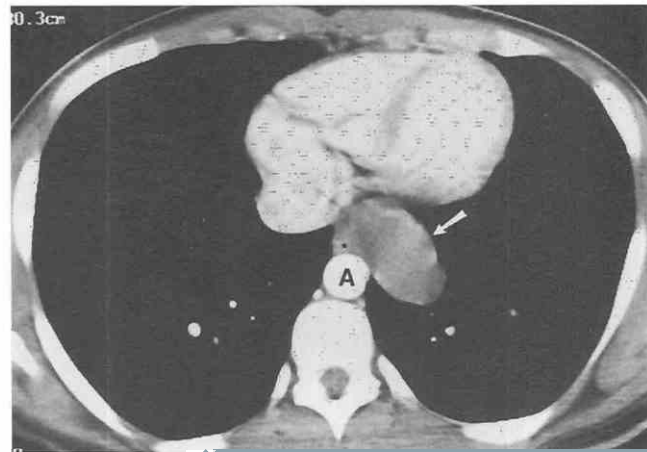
Esophageal duplication cyst. Contrast-enhanced CT shows a well-marginated, low-attenuation middle mediastinal mass (arrow) adjacent to the left lateral wall of the esophagus (asterisk). Note the lack of enhancement. A, aorta.
